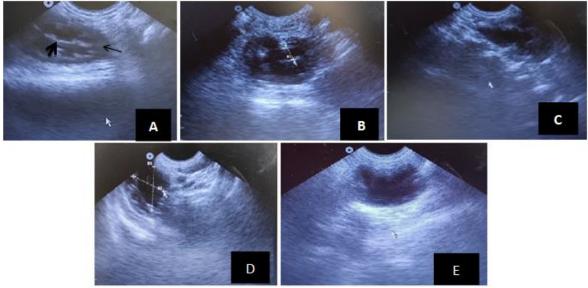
ultrasonography for kidney after induction of complete unilateral ureteral ligation (group A) (A) normal kidney before induction of hydronephrosis. (B) 7 days post ligation, kidney size has increased. (C) 14 days post ligation reveals observable dilation of renal pelvis. (D) 21 days post operation, renal parenchyma has degenerated, and renal pelvis continued to increase in size. (E) the kidney 28 days post ligation; the cortex is indistinct from medulla, hydronephrosis became clear, kidney appeared as a water sac. thin arrow: cortex, thick arrow: medulla
